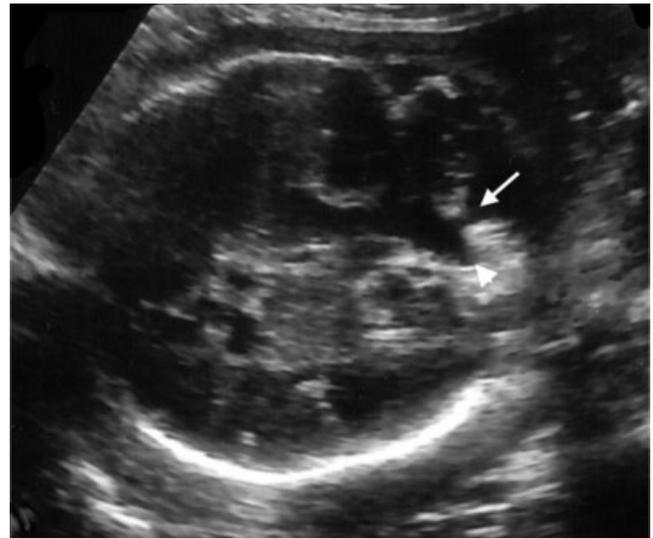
Ultrasound image showing sonographic appearance of the same lesion as in Figure 1 after 8 weeks. Note the large gap between the cerebellar hemispheres indicating complete absence of the vermis (arrow). There was also enlargement of the fourth ventricle due to destruction and hypoplasia of the left cerebellar hemisphere (arrowhead).
